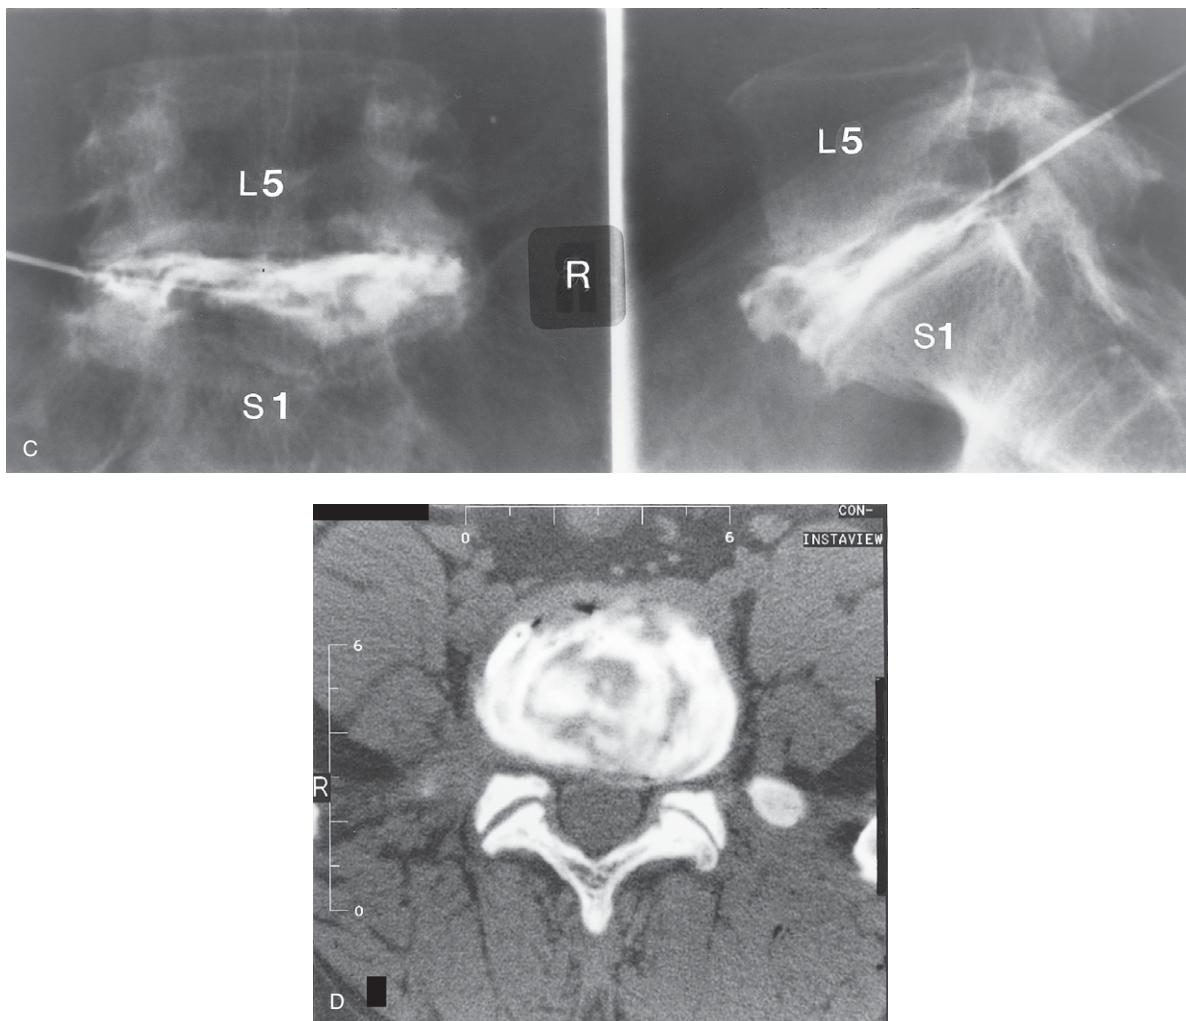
Cont'd (C) Anteroposterior and lateral discograms of the lumbosacral disc (L5–S1) showing the internal disc disruption and extravasation of contrast material during injection. (D) L5–S1 intervertebral disc CT axial image view showing significant internal disc disruption with loss of the normal annular fibres and extravasation from the disc across the endplates and into the paravertebral soft tissues.
